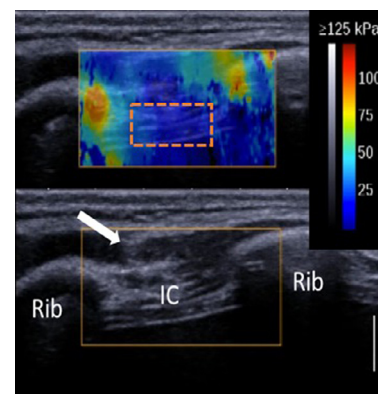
Example of elastography image (top) and ultrasound (bottom) of intercostal muscles in an 11-y-old girl. The white arrow shows the limit between the serratus anterior and latissimus dorsi. The intercostal muscles are visible between the ribs. The dashed rectangle is the region of interest in the intercostal muscles.
